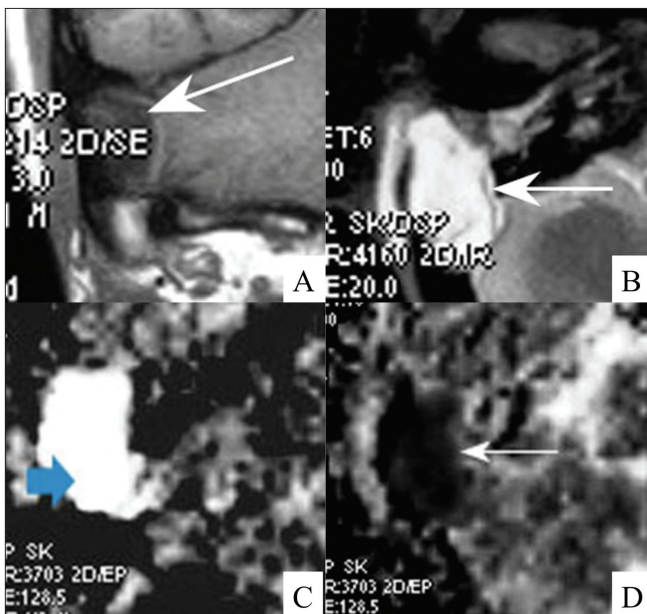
(A-D): Cholesteatoma of the EAC: coronal T1W MRI image (A) shows a hypointense lesion (arrow) in the right temporal bone. Axial STIR MRI image (B) shows a hyperintense lesion (arrow) extending into the mastoid. Diffusion-weighted (C) and axial apparent diffusion coefficient (ADC) (D) images show restricted diffusion (arrows)
